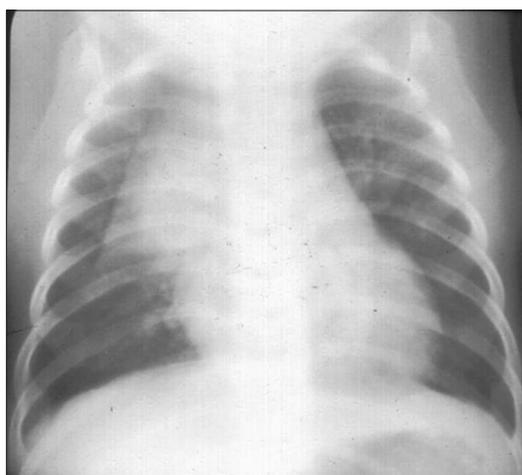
Chest X-ray of Case number 6.
